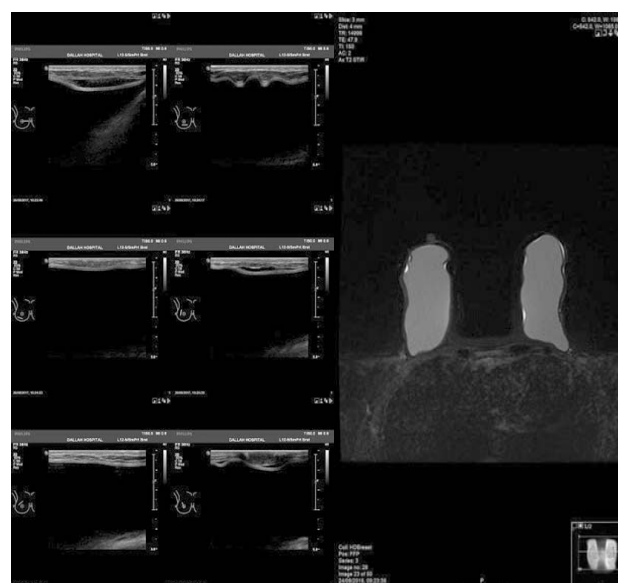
False positive case due to reverberation artifact mimicking an intracapsular rupture. No rupture seen on MRI.
